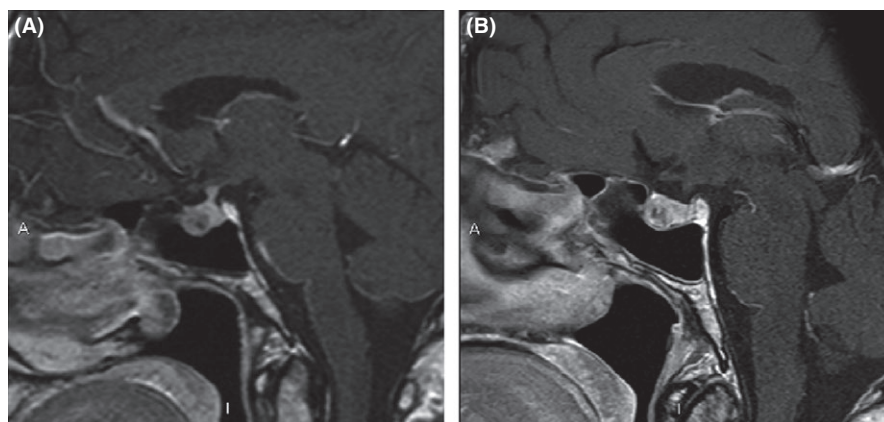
Contrast enhanced T1-weighted MR images of the pituitary gland in a patient with thyrotropin-secreting pituitary adenoma. (A) Before starting treatment with Pasireotide LAR, an area with inhomogeneous diminished enhancement is seen, ventrally in the pituitary gland, consistent with a microadenoma (size of 7 × 8 × 12 mm). (B) After 4 months of treatment with pasireotide LAR. Although scanned at a slightly different angle, the plane through the pituitary is similar and suggests a stable size of the TSH-oma with increase in peripheral enhancement and a more hypointense centre, possibly representing degeneration
